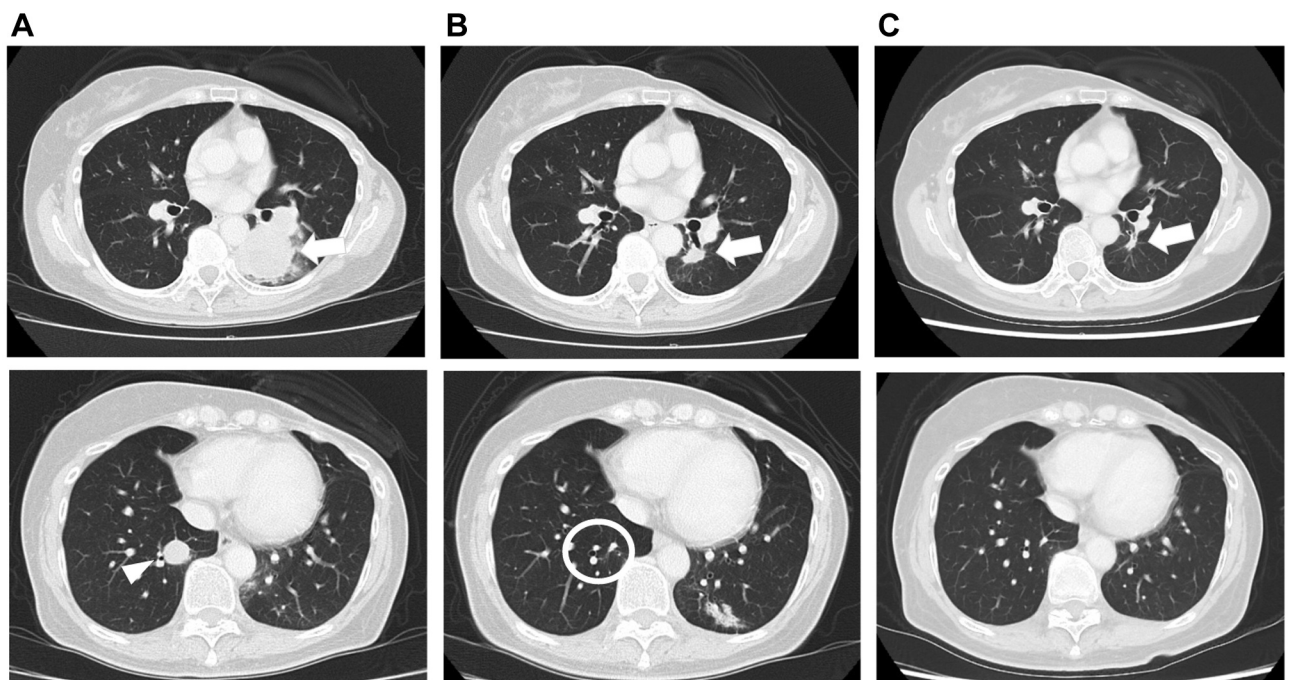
Computed tomography imaging during treatment with pembrolizumab, carboplatin, and gemcitabine. A) Before treatment, multiple lung metastases were observed (white arrow and arrowhead). B) After 3 months of treatment, the tumor shrank (white arrow) and disappeared (white circle). C) After 12 months of treatment, the tumor continued to reduce (white arrows).
